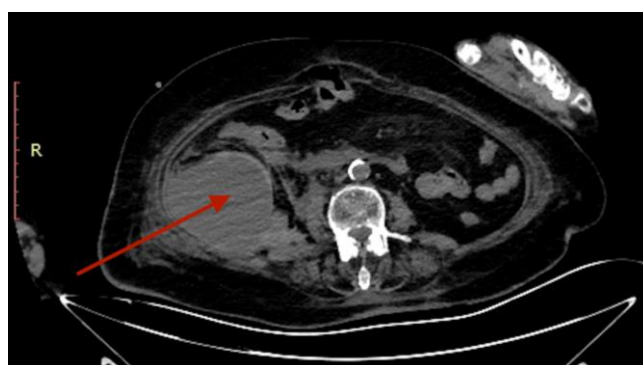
Axial abdomen CT section of Case 3: right retroperitoneal hematoma extending to the right femoral region
